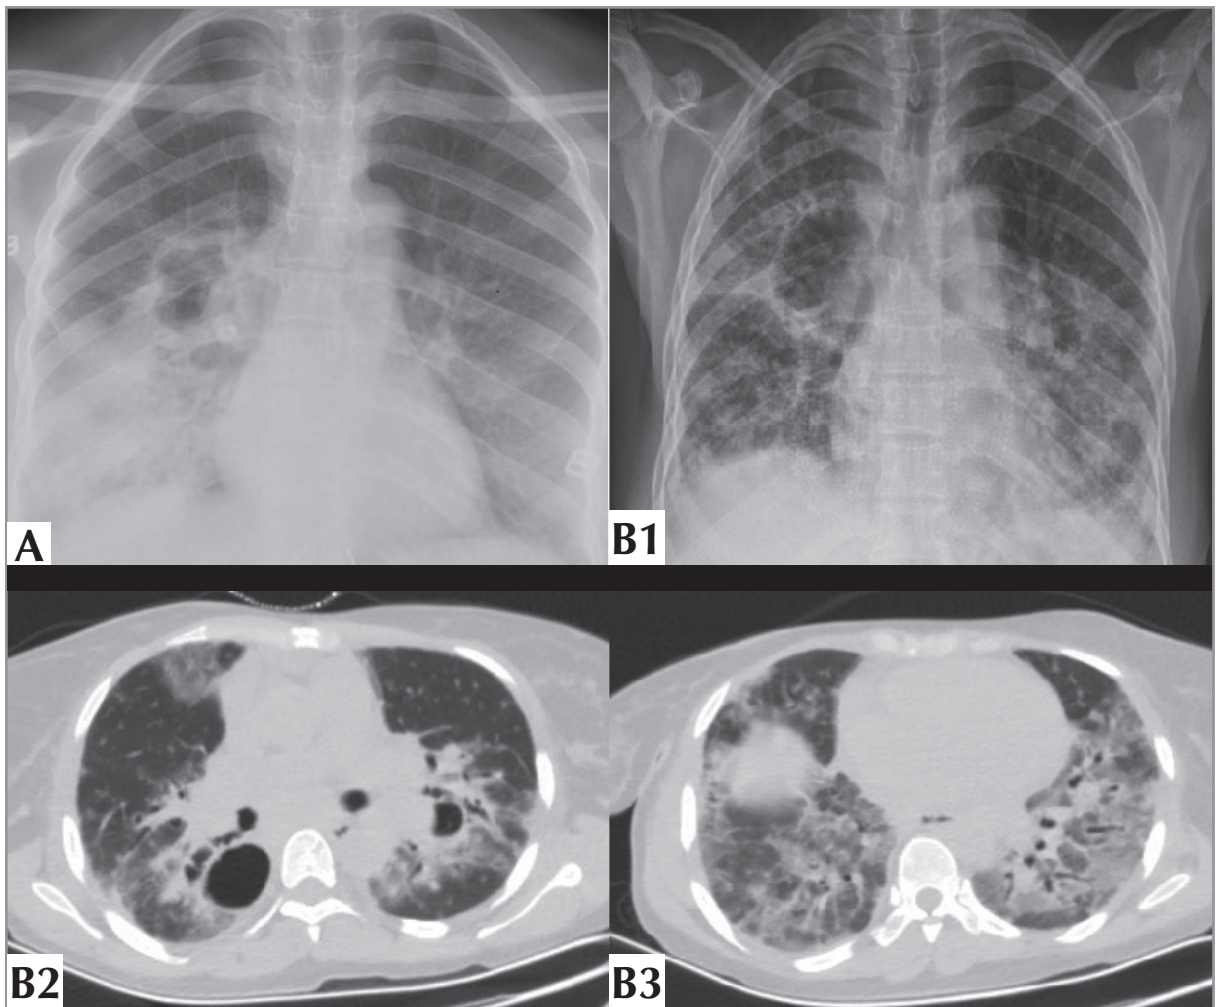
A. Chest X-ray at the beginning of tuberculosis diagnosis B1, B2, B3- Chest X-ray and Thorax CT at the beginning of COVID 19 diagnosis.
